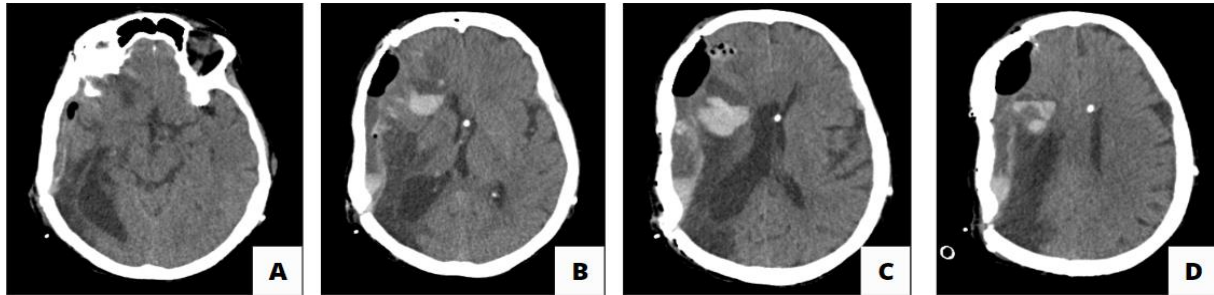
CT sections presenting intraparenchymal hemorrhagic lesion, with parenchymal expansion and midline deviation.
